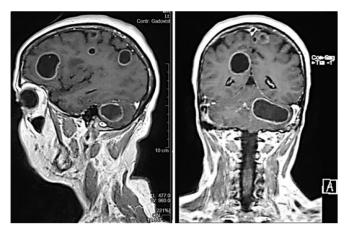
magnetic resonance imaging of cerebral cystic echinococcosis. A magnetic resonance imaging (MRI) of the brain revealed multiple cystic encephalic lesions. The cysts were hypo- to iso-intense on T1 and DWI and hyperintense on T2. After contrast administration, peripheral rim enhancement was revealed on the MRI.
